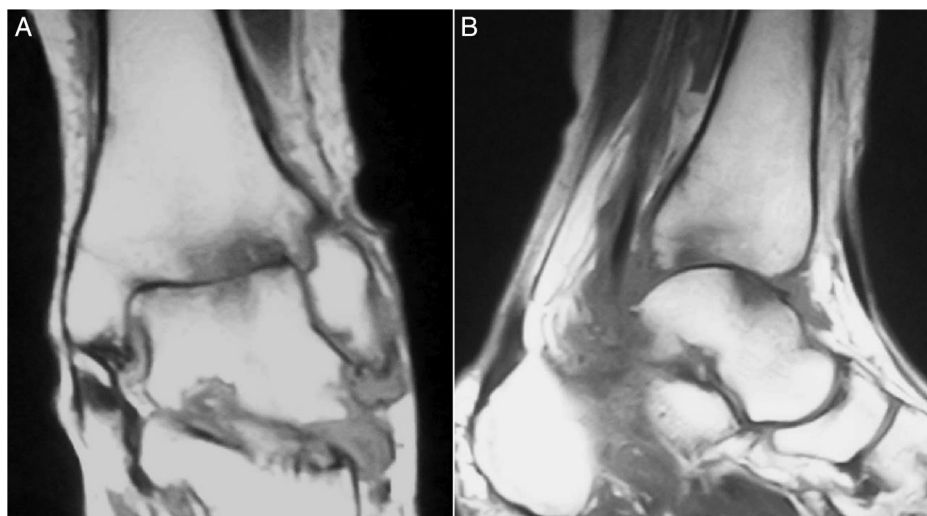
Preoperative magnetic resonance imaging scan of the ankle. Coronal (A) and sagittal (B) magnetic resonance imaging scan revealing articular cartilage disappearance and a T₁-weighted low-intensity area in the subchondral bone of the talus and tibia, indicating the change in the subchondral bone structure associated with cartilage degeneration.
